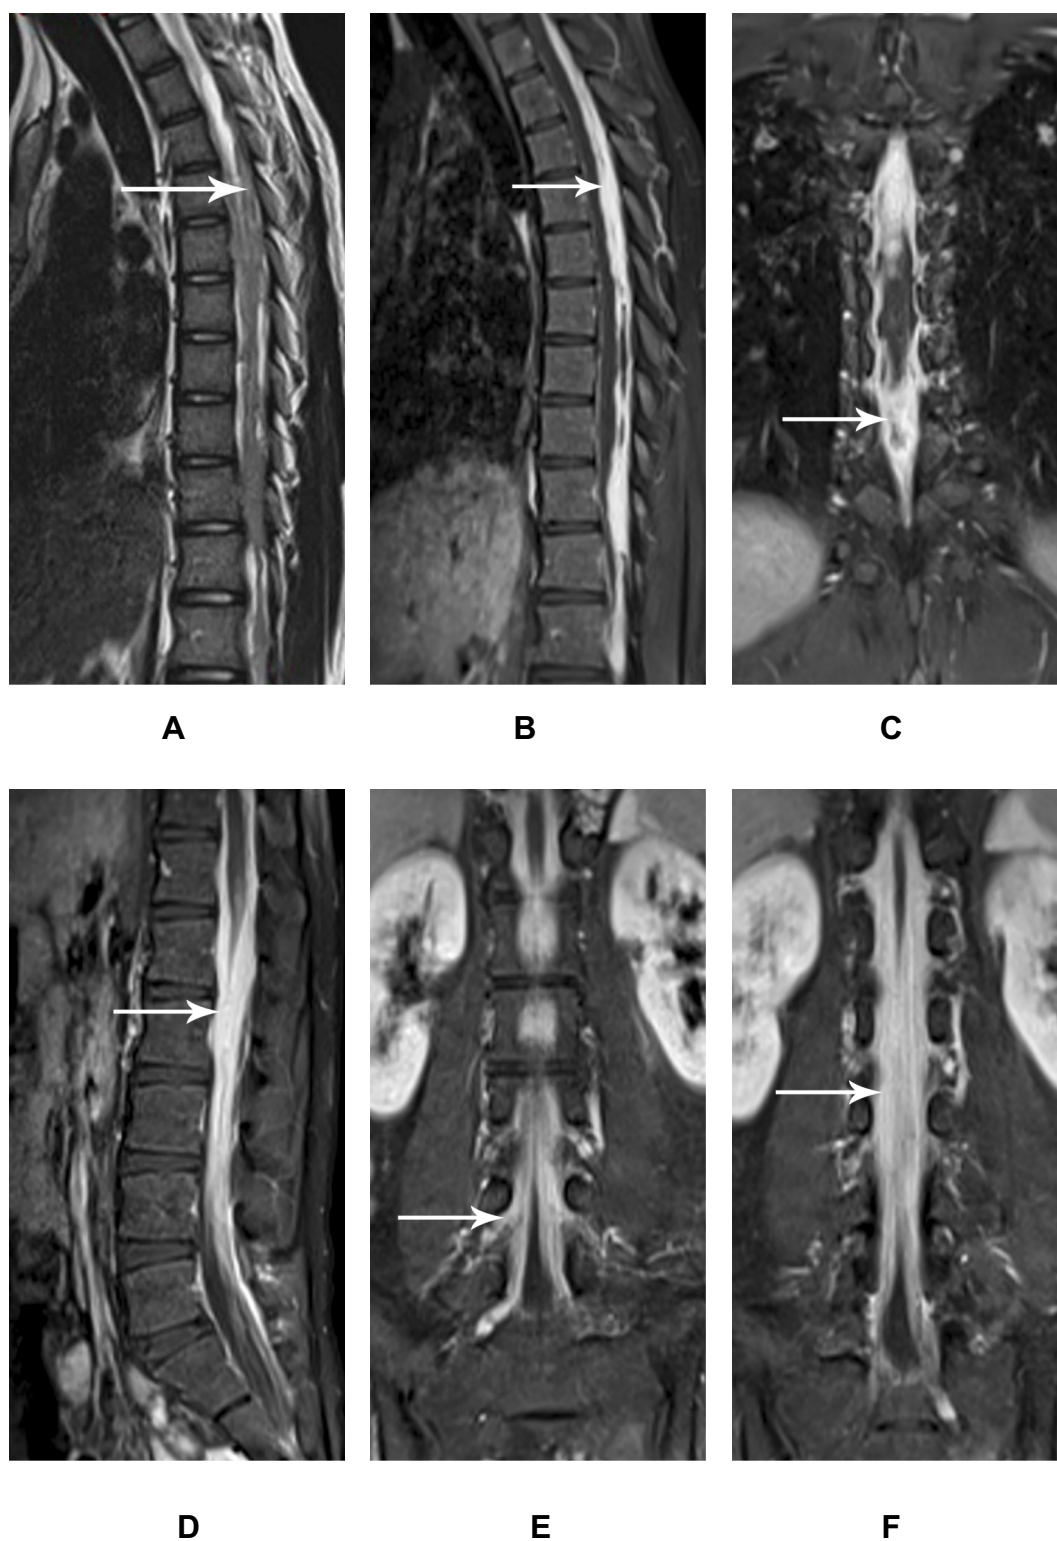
The irregularly thickened meninges of intraspinal tuberculosis show obvious homogeneous enhancement on MR images.
